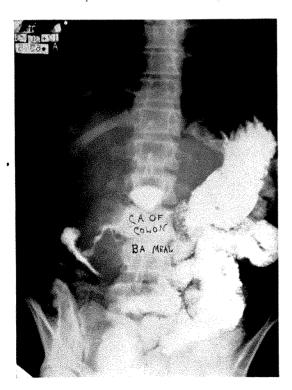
Roentgenogram after administration of an opaque meal.
